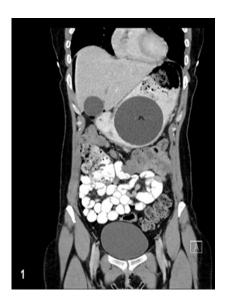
Coronal CT scan showing free intraabdominal air and intragastric balloon.
